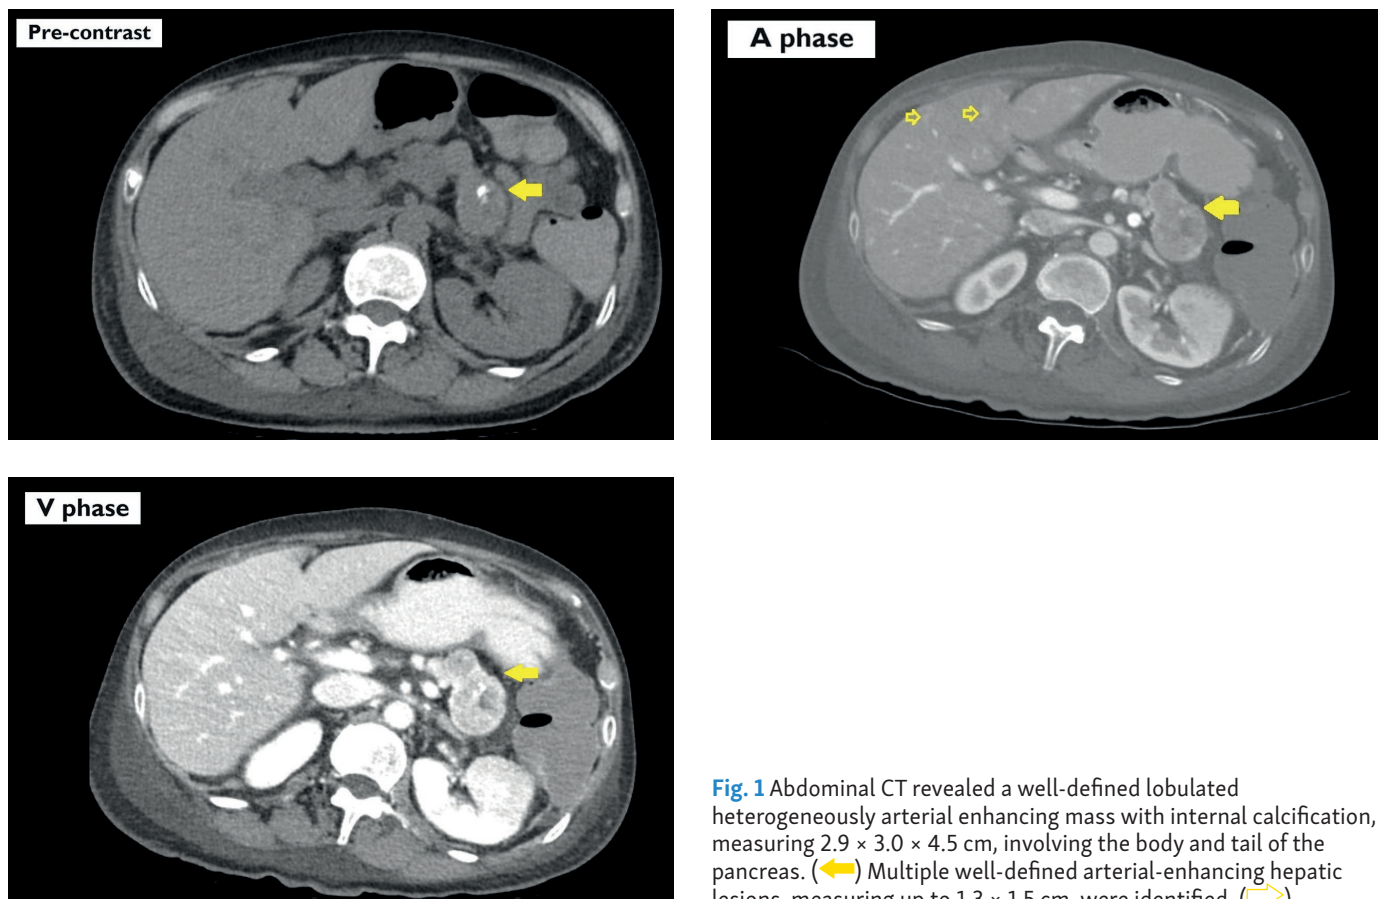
Abdominal CT revealed a well-defined lobulated heterogeneously arterial enhancing mass with internal calcification, measuring 2.9 × 3.0 × 4.5 cm, involving the body and tail of the pancreas. (←) Multiple well-defined arterial-enhancing hepatic lesions, measuring up to 1.3 × 1.5 cm, were identified. (⇨)
